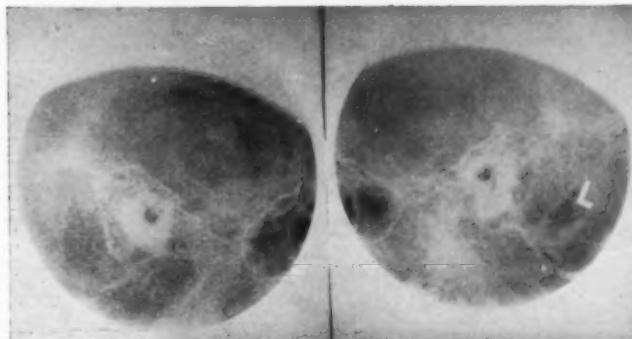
Case 2.—Preoperative roentgenogram showing almost equal pneumatization and cell clarity of both mastoids.
